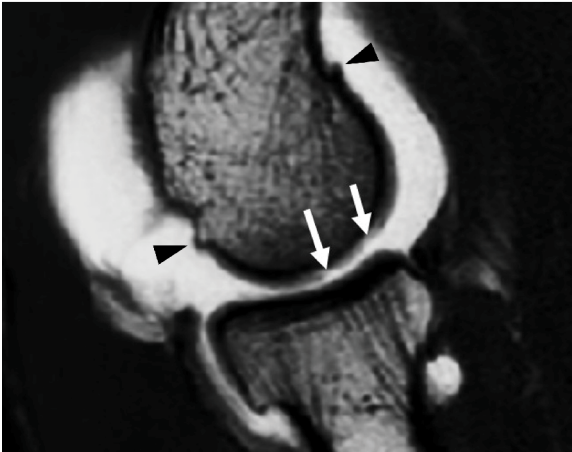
Sagittal T1-weighted image: erosive chondropathy of the capitulum humeri: to note tiny irregularities of the cartilage surface (with the arrows) and small osteophytes (black arrowheads).
